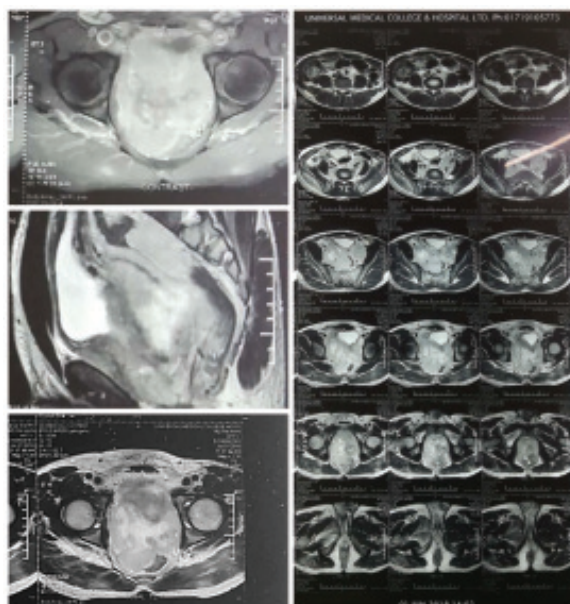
MRI of pelvis shows a lobulated heterogenous soft tissue mass from the prostate. Hypointense on T1 & hyperintense on T2 is observed. Mass invades the neck & base of the urinary bladder. Seminal vesicles and anterior wall of rectum are adherent and inseparable from the mass. Post contrast images revealed heterogenous enhancement of the mass. No ascites, lymphadenopathy or collection is noted.
